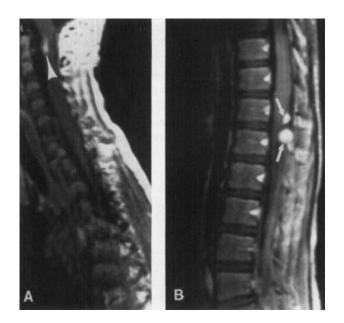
A: Post-contrast sagittal T1-weighted image of the cervical spine performed in February 1993 on patient in Case 2 demonstrates an enhancing nodule located in the anterior portion of the cervical cord at the level of C2 (arrowhead). B: In the lumbar spine region, two enhancing masses are identified near the conus medullaris (arrows).
